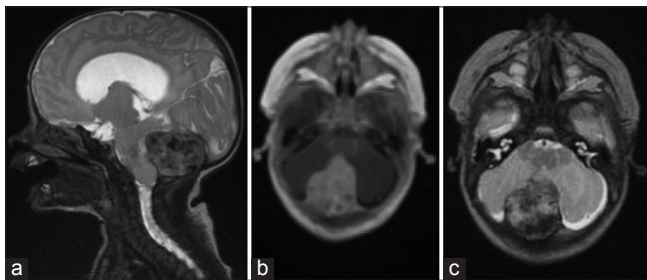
Preoperative images. (a) Sagittal T2 image demonstrating a heterogeneous posterior fossa lesion with compression of the cerebellum and enlargement of the supratentorial ventricles. (b) Contrast-enhanced axial T1 image of the posterior fossa lesion demonstrating avid contrast enhancement. (c) Axial T2 MRI showing significant heterogeneity within the lesion with effacement of the fourth ventricle
